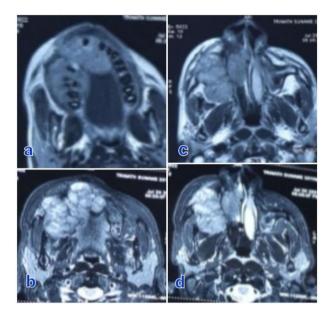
(a-d): CE MRI NOSE PNS showing Illdefined heterogeneously enhancing lobulated lesion
